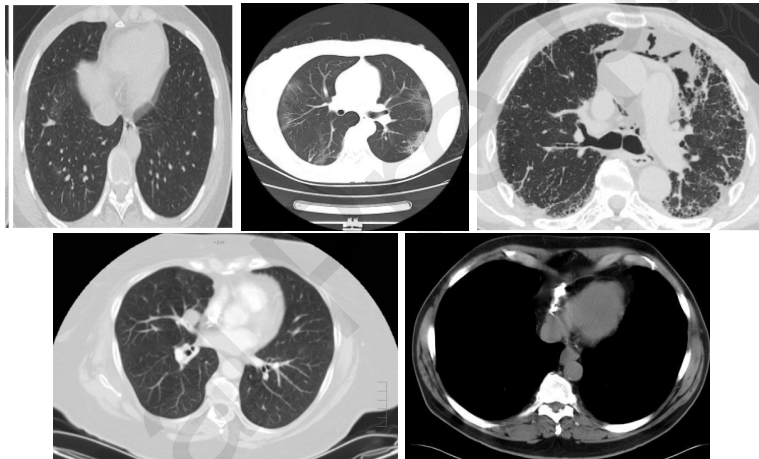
The 5 derived cluster centers in the CT-image Database; the 3 top ones correspond to the non-COVID-19 category and the 2 bottom ones correspond to the COVID-19 category
